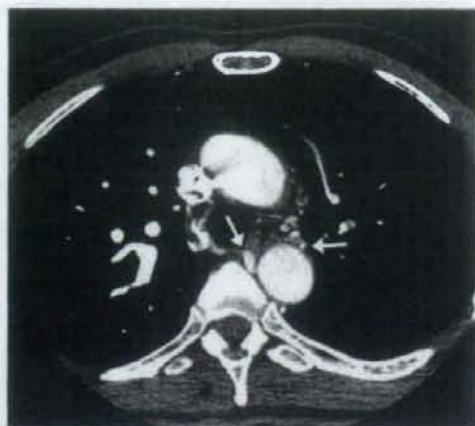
Computed tomography angiography in a patient with chronic thromboembolic pulmonary hypertension shows dilated bronchial arteries (arrows).
